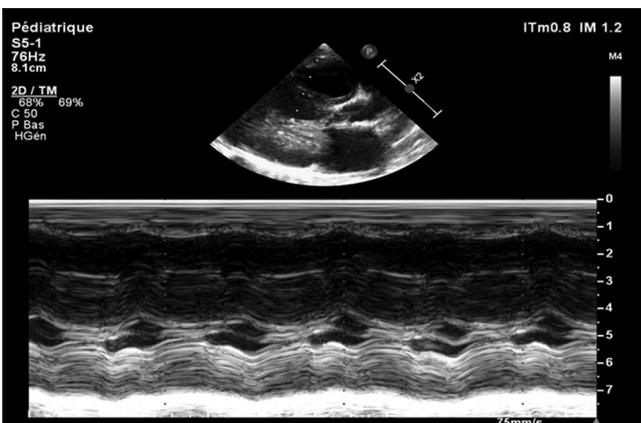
M-mode parasternal long axis view revealing the left ventricular hypertrophy
